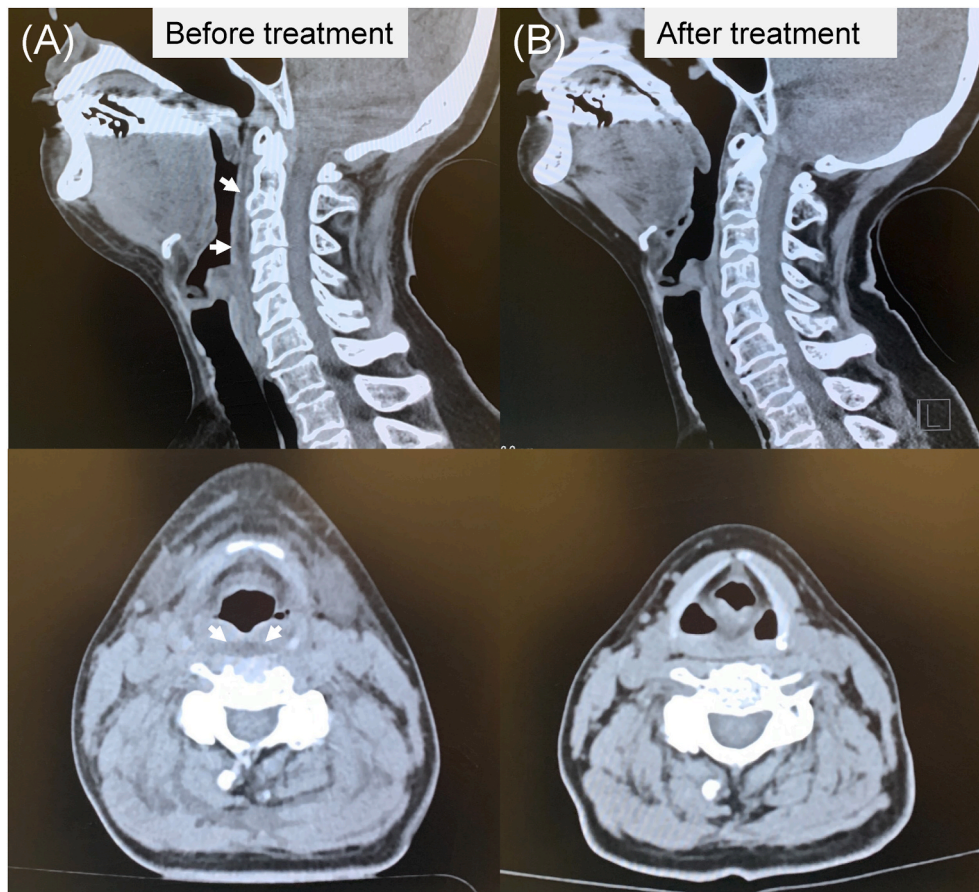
(A) Neck computed tomography (CT) showing prevertebral thickening with edema (white arrows). (B) Resolution of retropharyngeal swelling seen on follow-up CT 2 months later.
